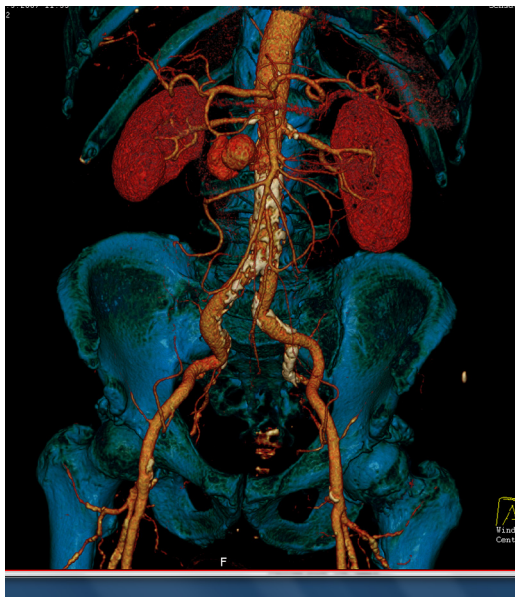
A typical CT scan of aortitis or mycotic aneurysm.
